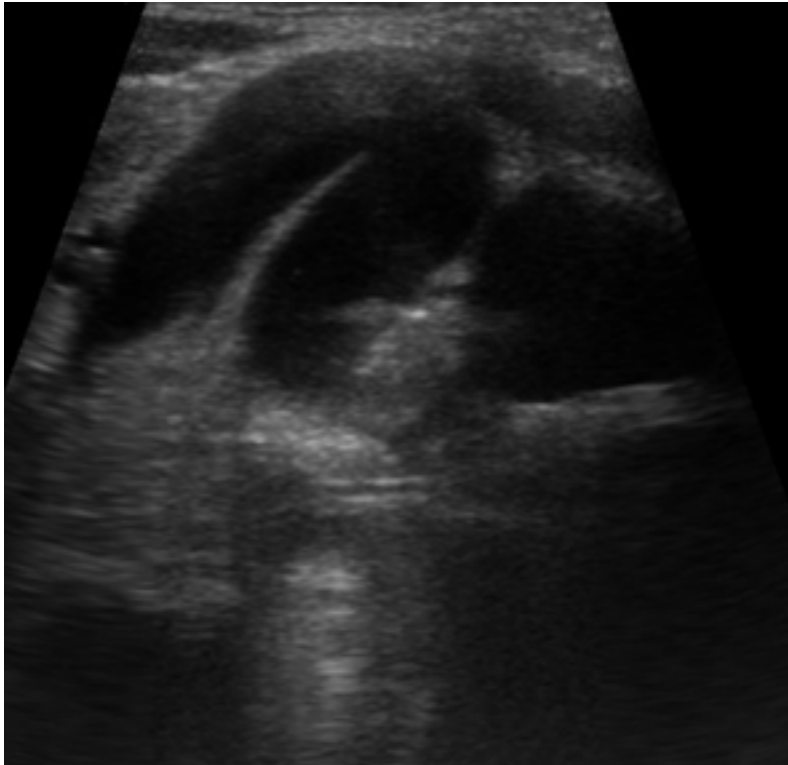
Ultrasound scan showing dilated and tortuous right ureter.
